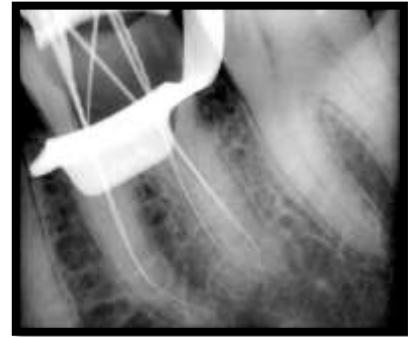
Working Length Estimation Radiograph
